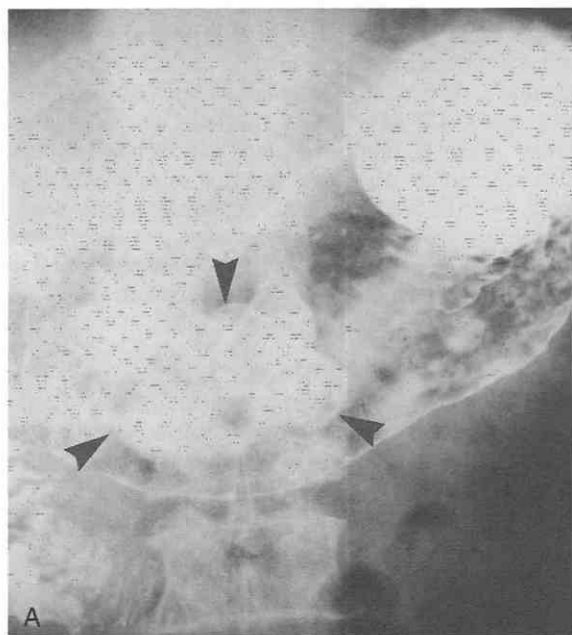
Gastroduodenal intussusception due to prolapsed gastric adenoma. *A*, Radiograph shows a large polypoid mass (arrowheads) in the antrum of the stomach. *B* and *C*, CT scans obtained 1 month later after an upper gastrointestinal series show large soft tissue mass (arrows) in the duodenum and beaklike narrowing (small arrows) of the distal stomach. (From Ha HK, Shinn KS, Kim IC, et al: Gastroduodenal intussusception due to a prolapsed gastric adenoma. *AJR Am J Roentgenol* 159:432, 1992.)
